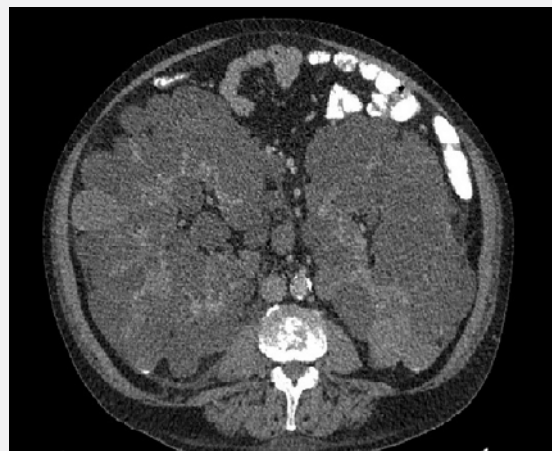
Computed tomographic scan shows multiple bilateral kidney cysts, resulting in enlargement of the organ.
